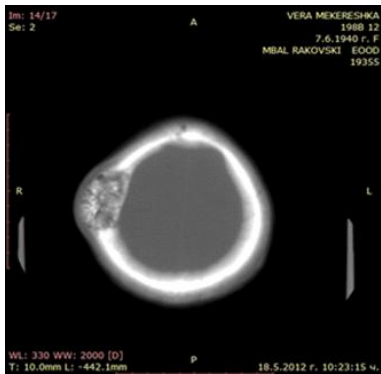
CT image of osteoma affecting the skull
